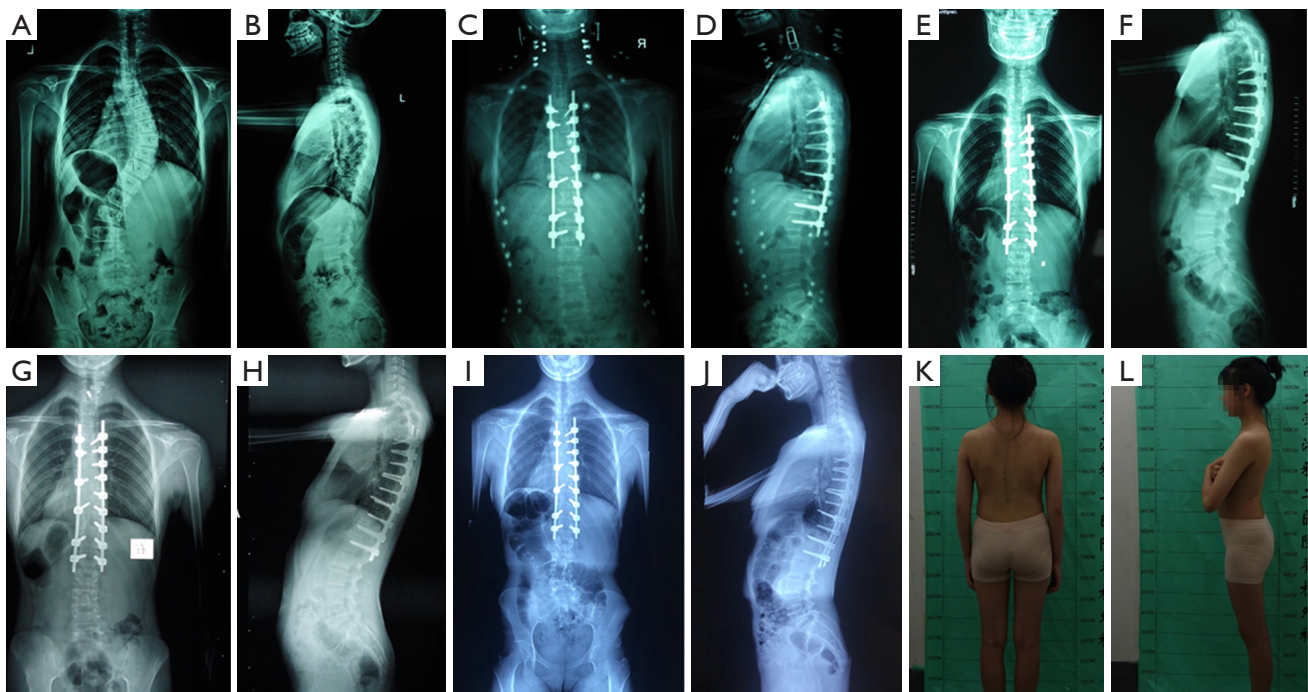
A 15-year-old girl diagnosed with adolescent idiopathic scoliosis (Lenke1 AN). (A,B) Preoperative spine X-ray showed the Cobb's angle of the main thoracic curve was 46°; the kyphosis angle of thoracic spine was 10°. (C,D) Spine X-ray 4 days after operation showed the Cobb's angle of the main thoracic curve was 9°, and the correction rate was 80.1%. (E-J) Spine X-ray 3–144 months after operation showed deformity correction was maintained. There were no signs of loosening of the internal fixation. In addition, there was an occurrence of a slight adding-on phenomenon, which did not affect the efficacy, so no further surgical intervention was taken. (K,L) Physical appearance of this patient 144 months after operation. Although a slight adding-on phenomenon occurred, self-image improved significantly. This image is published with the consent of the patient's guardians.
